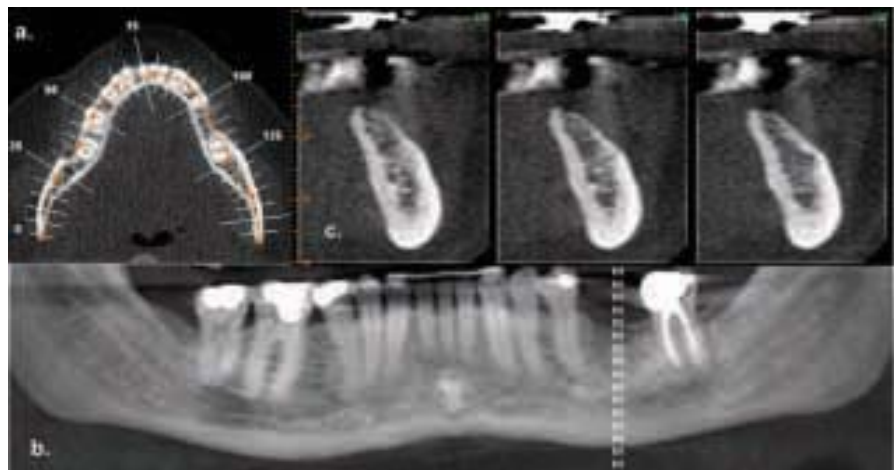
CBCT applications in implant site assessment. A curved planar MPR is accomplished by aligning the long axis of the imaging plane with the dental arch (a.), providing a region panorama-like thin-slice image (b). In addition serial thin slice trans-planar images are generated (c.), useful in the assessment of specific morphologic features such as the location of the inferior alveolar canal for implant site assessment as well as allowing measurement so the available alveolar bone height and width. (Volumetric data set acquired with iCAT).
